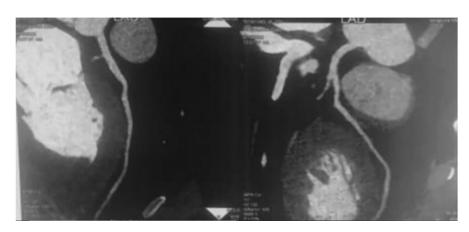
Computed tomography angiogram revealed reduction of thrombus burden.
